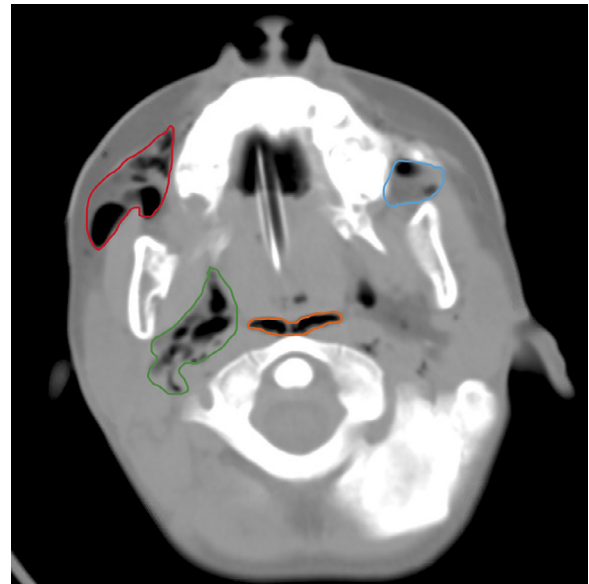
Axial view of a computed tomography (CT) head scan without contrast at the level of C1. There is prominent air surrounding the masticator, parotid, and lateral pharyngeal spaces (green), the retropharyngeal space (orange), the right buccal space (red), and the left buccal space (blue).
